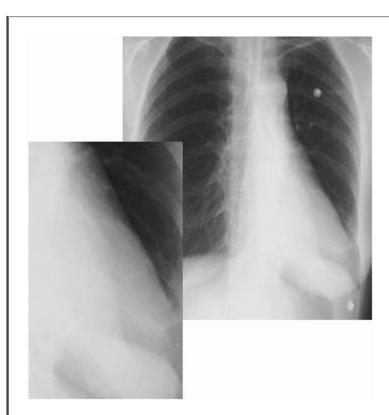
Radiograph showing left lower lobe collapse—note the 'sail-shape' of white behind the heart.
